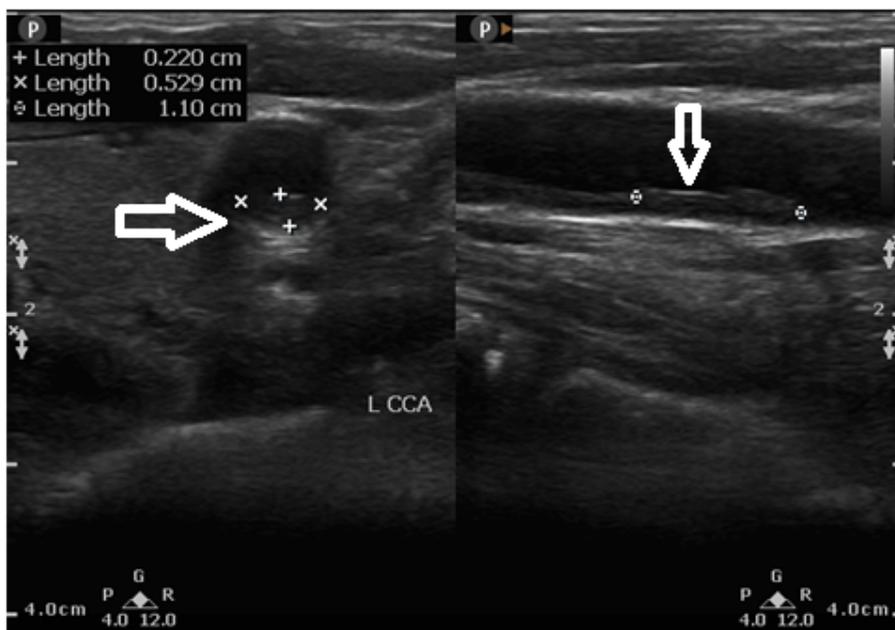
B-mode (gray scale) ultrasound image of longitudinal (Rt arrow) and transverse (LT arrow) scan of Lt common carotid artery (L CCA) shows atheromatous plaques in RA patient.
